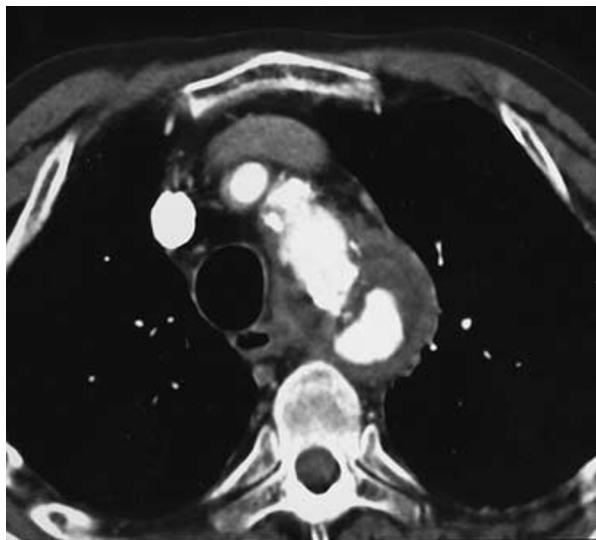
CT angiography. Transverse image at the level of the aortic arch showing extraluminal contrast medium adjacent to the aortic arch surrounded by a rim of soft tissue compatible with hematoma.
